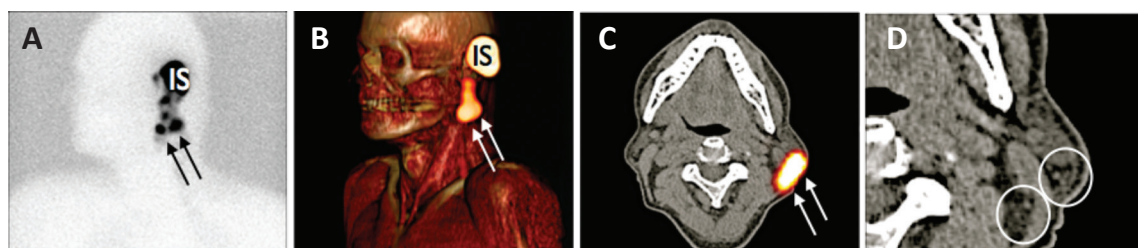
Preoperative sentinel node mapping in a 59-year-old male patient with head-and-neck melanoma (left ear; Breslow thickness 1.0 mm). The patient was scheduled for re-excision of the melanoma scar and subsequent SN biopsy. Due to the location of the melanoma, no patent blue dye was injected intraoperatively. Conventional lymphoscintigrams (A) and SPECT/CT images (B) showing SNs in the parotid gland and level II
